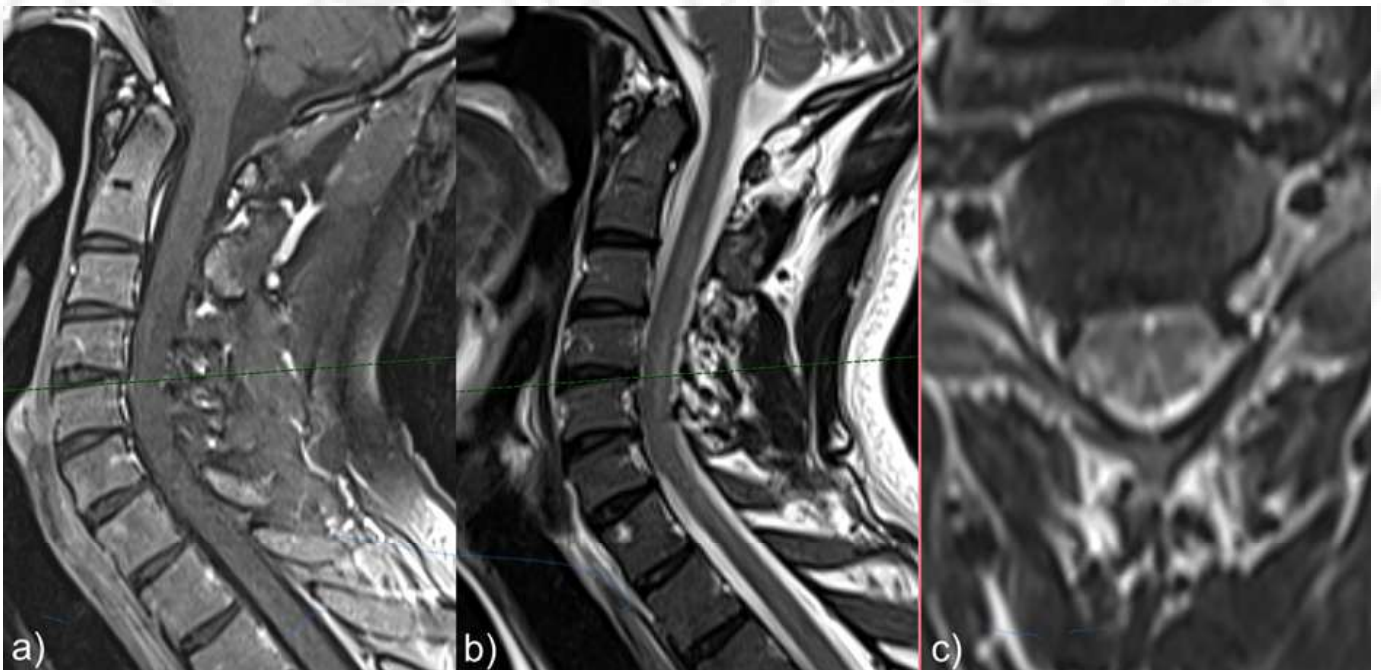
(a) Post-contrast sagittal T1-fat, (b) T2-weighted sagittal, and (c) T2-weighted axial magnetic resonance images showing a signal change in the spinal cord, without contrast enhancement, affecting the lateral and posterior fasciculi at the cervical level.
